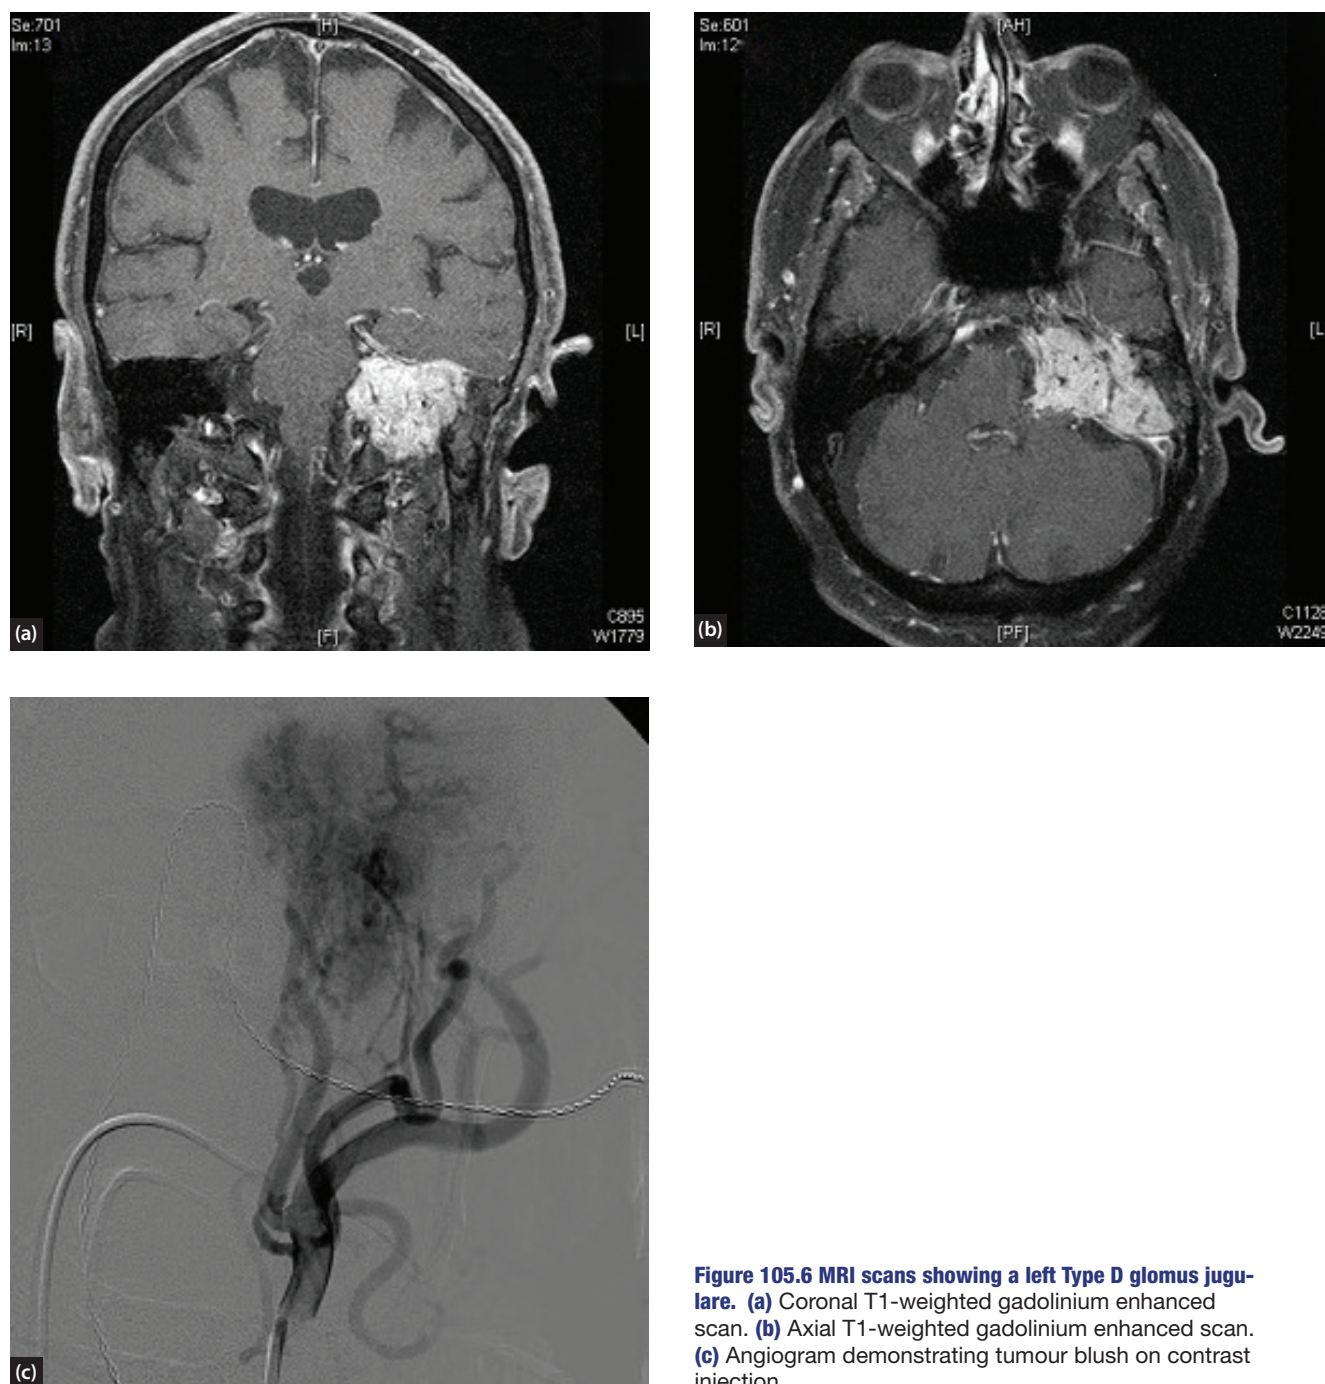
MRI scans showing a left Type D glomus jugulare. (a) Coronal T1-weighted gadolinium enhanced scan. (b) Axial T1-weighted gadolinium enhanced scan. (c) Angiogram demonstrating tumour blush on contrast injection.
